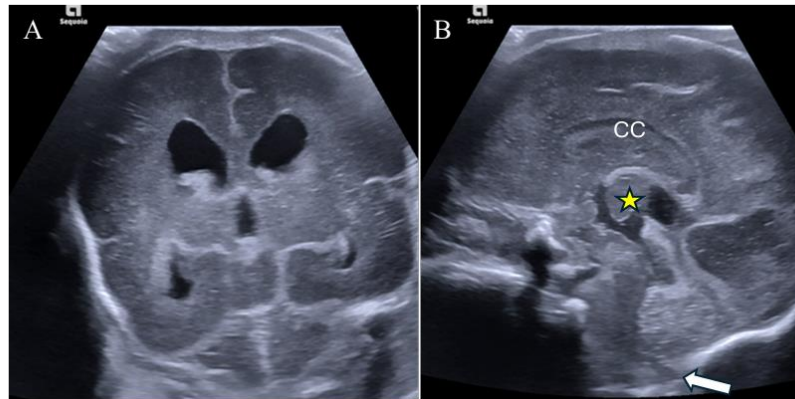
Admission head ultrasound A) coronal view showing mild-moderate ventriculomegaly and B) midline sagittal view showing the presence of corpus callosum (CC), interthalamic adhesion (yellow star), and small posterior fossa with hindbrain herniation consistent with Chiari II malformation (white arrow).
